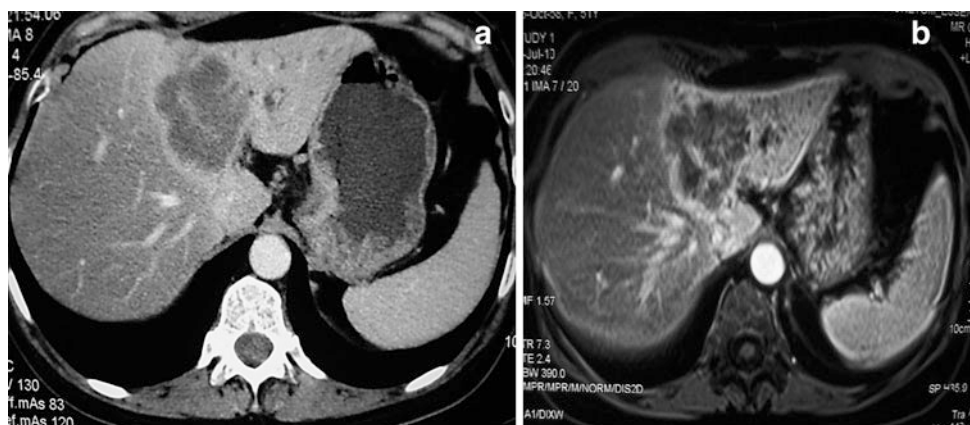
Radiological aspects on CT and MRI of intrahepatic cholangiocarcinoma. Note the heterogeneous enhancement, left lobe atrophy and biliary dilatation
